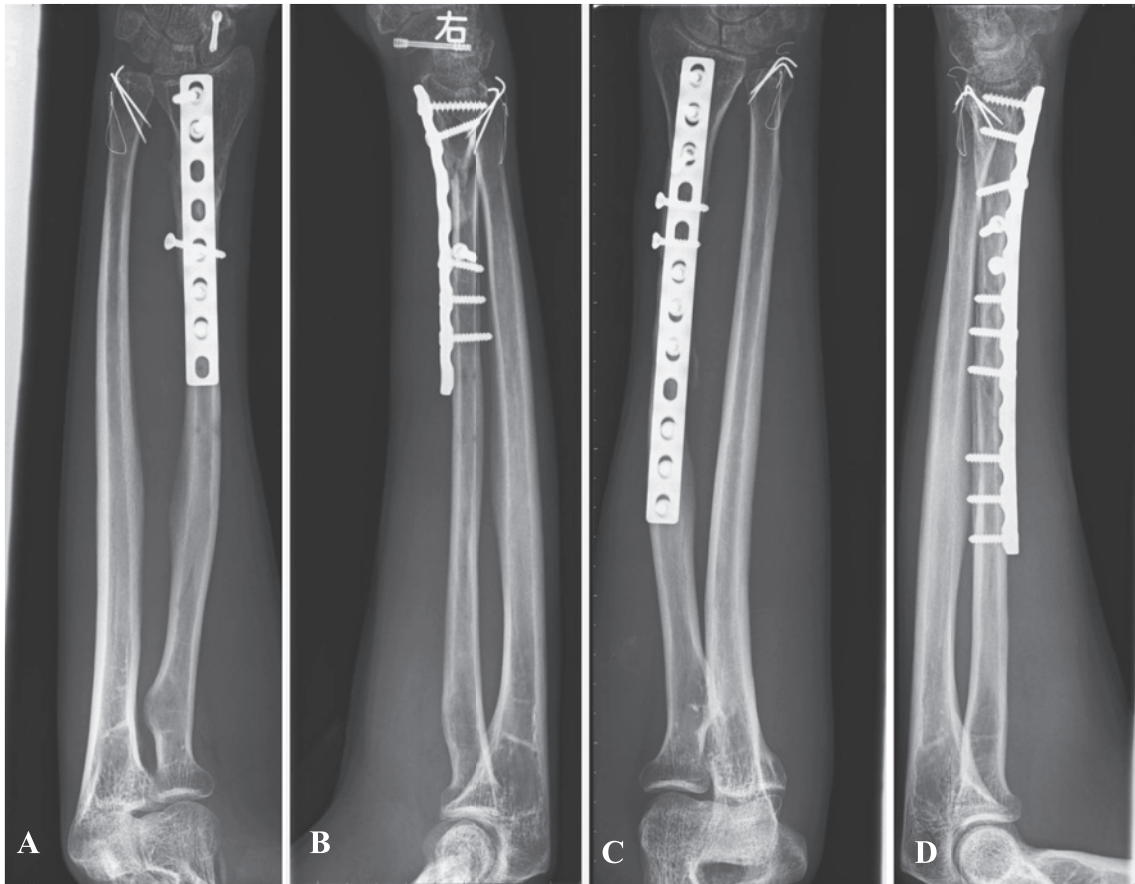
Postoperative radiographs of the forearms show good reduction and fixation of both the bilateral distal Galeazzi fractures and the fracture of the right scaphoid: posteroanterior view of the right forearm (A), lateral view of the right forearm (B), posteroanterior view of the left forearm (C), lateral view of the left forearm (D).
